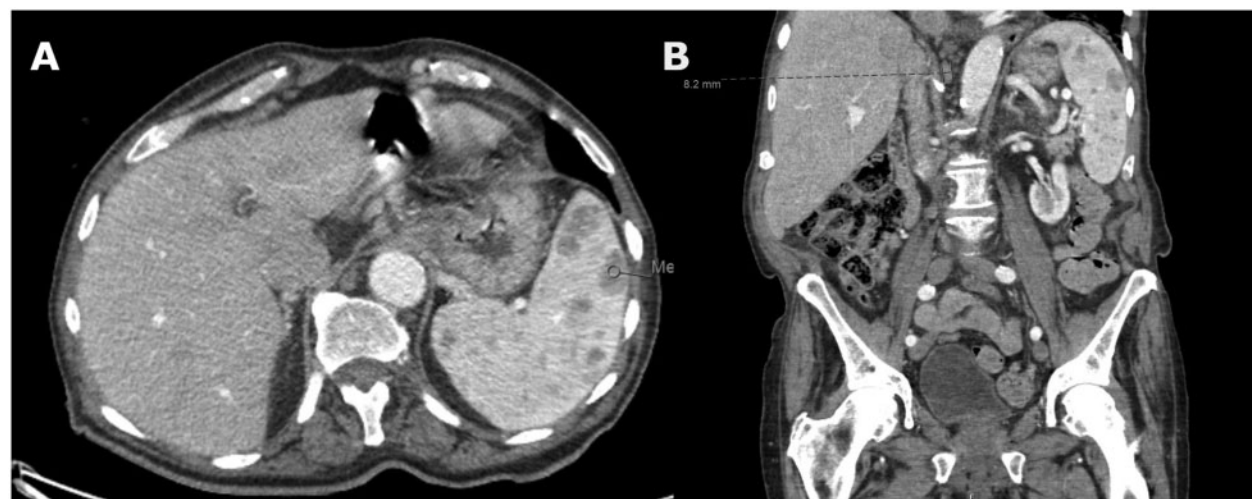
Retroperitoneal lymphadenopathy demonstrated on computed tomography angiogram abdomen with axial view (A) and coronal view (B).
